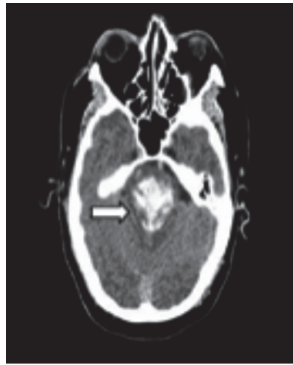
(C): Axial Plain CT Brain Image Showing the Pons
